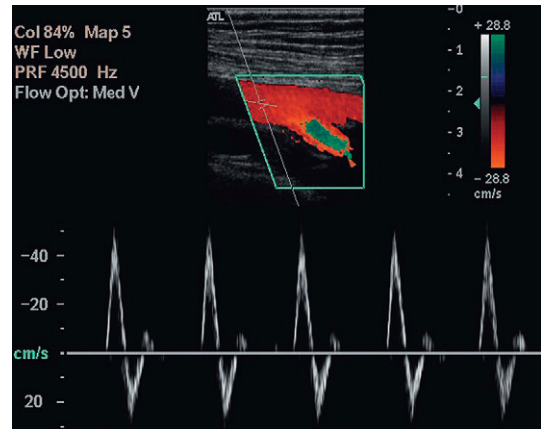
The normal femoral artery waveform. (a) In a limb at rest three components are visible. Aliasing in the profunda artery is due to the lower insonation angle giving a higher Doppler shift, not a focal stenosis. (b) Following exercise there is increased flow throughout diastole as a result of peripheral dilation.
